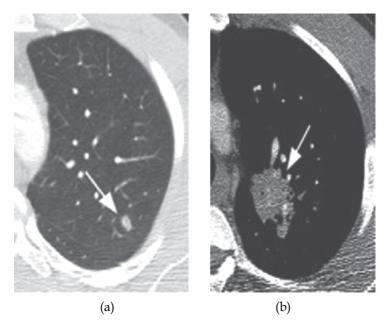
Pulmonary macronodules and masses in sarcoidosis. (a) A 34-year-old male. CT of the chest shows a 12 mm nodule in the left upper lobe. (b) A 39-year-old male. CT of the chest demonstrates a large soft tissue mass in the left upper lobe. Biopsy confirmed non-caseating granulomatous disease in both patients.
